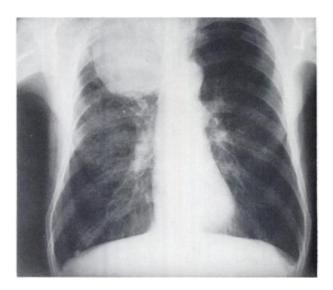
Chest radiograph of patient. Note large right upper lobe lesion.
